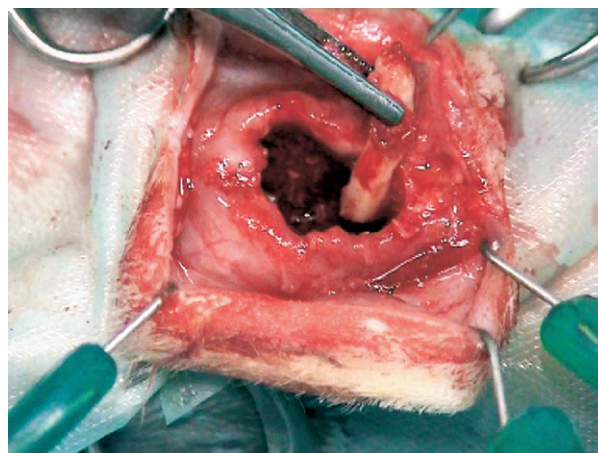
Complete removal of the capsule of a periapical abscess at the point where the abscess connects with the bone.
